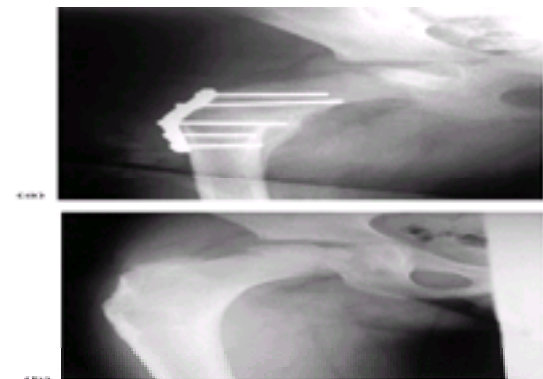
(a) Radiographs of the same patient in [Fig. 3](#), after varus osteotomy. (b) Following hardware removal the femoral head is seen to have remodeled to a more round shape and is better contained within the acetabulum than was seen on preoperative radiographs.
